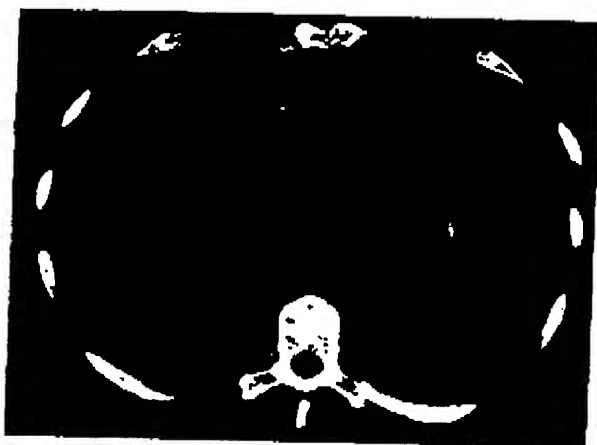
Axial CT scan through the mid-portion of the heart in a patient operated by pericardial closure with a PHB patch 6 months earlier. The patch (open arrow) and the presence of fat between the patch and cardiac surface (closed arrows) is clearly seen. The fat indicates that the space between the patch and the cardiac surface is free of postoperative adhesions.
